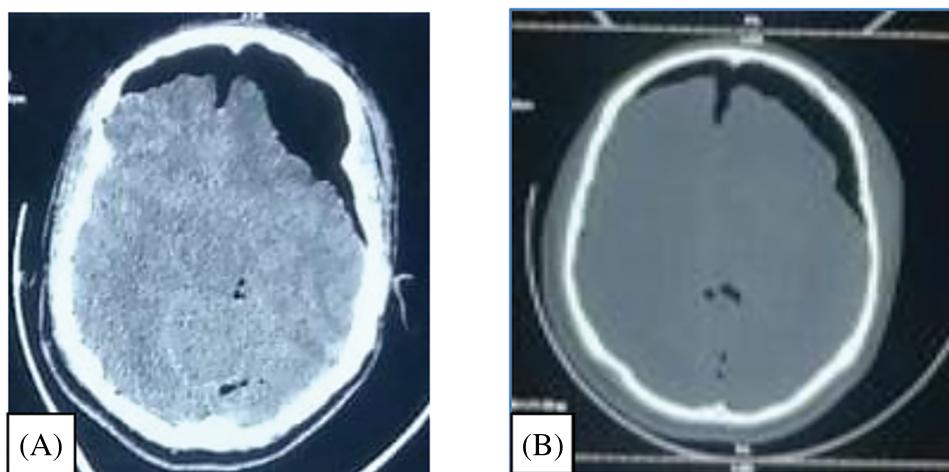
Axial-slice CT scan of the brain showing diffuse pneumocephalus: A) parenchymal section and B) bone section.
